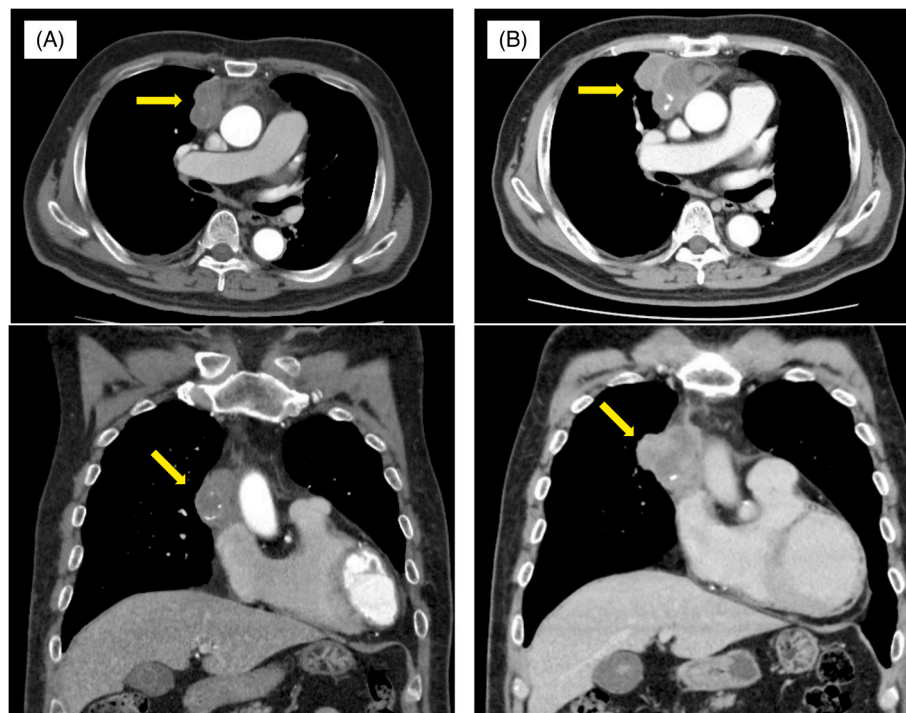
Chest CT images of the patient before surgery. (A) Contrast-enhanced CT images of the chest at the initial visit. A bifurcated, multinodular mass with a maximum diameter of 60 mm and coarse internal calcification in the anterior mediastinum (arrows) was noted. (B) The anterior mass rapidly progressed one month after the first visit.
